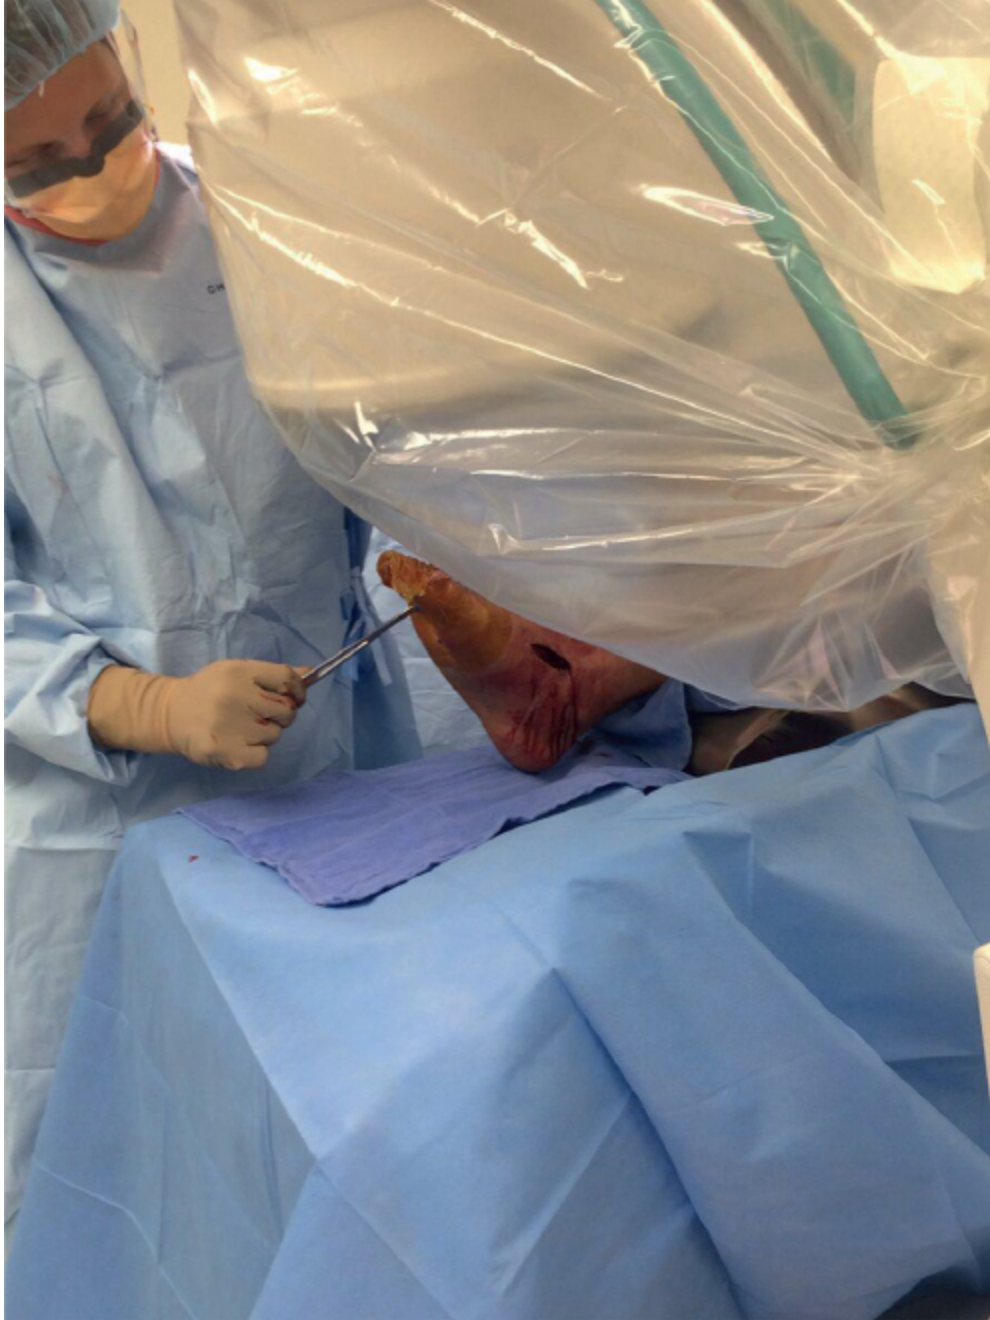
Intraoperative mortise view of the ankle. Note the position of the C-arm as well as the army/navy retractor that can assist in obtaining accurate radiographs while minimizing direct radiation to the surgeon's hands.
